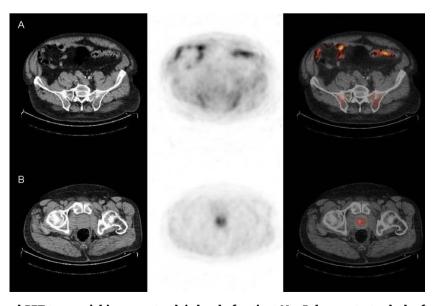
Conventional and PET transaxial images at pelvic level of patient No. 5 demonstrates lack of pathological tracer accumulation in 4 LN metastasis along the left iliac artery (A) but an increased Choline uptake (SUV = 2.5) in the prostatic tumor (B).
